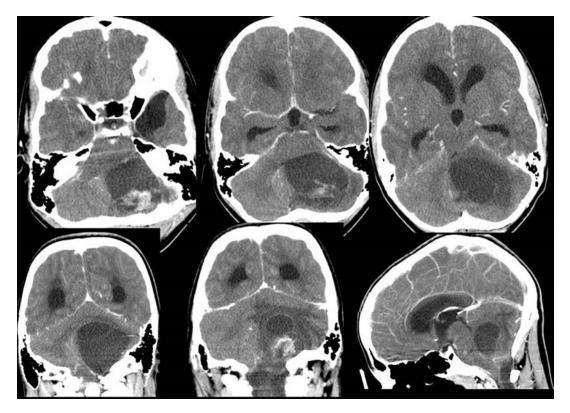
Computed tomography (CT) findings of posterior fossa cystic lesion with enhancement of mural nodule and significant associated hydrocephalus. (https://www.
